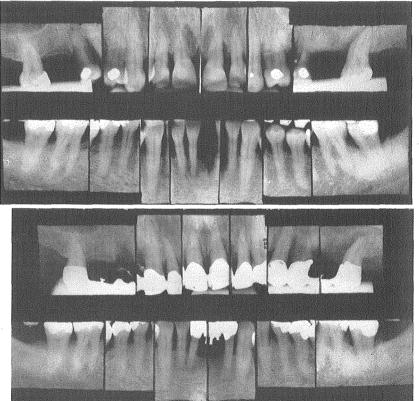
Roentgenograms and models made before treatment.
